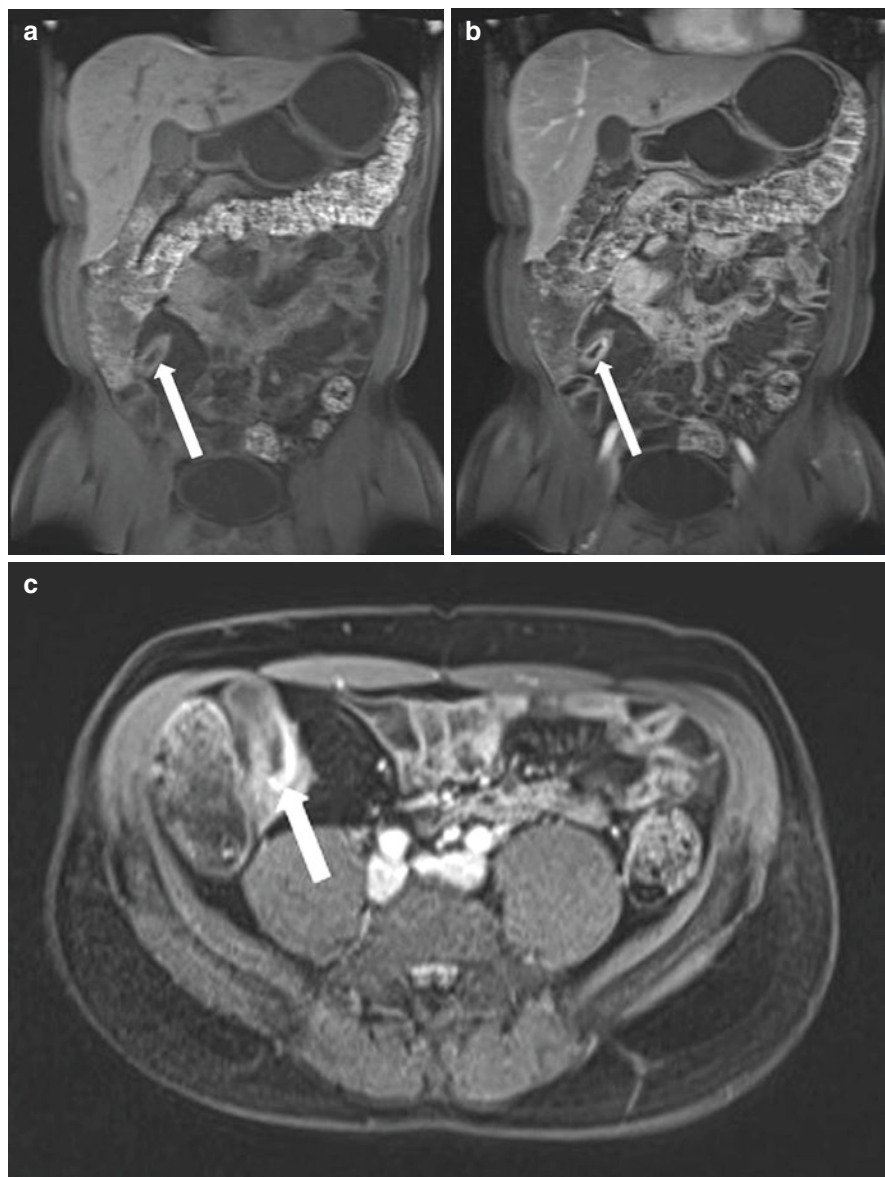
Typical hyper-enhancement of active terminal ileal (*arrow*) Crohn's disease after IV gadolinium administration. (a) Pre-contrast coronal T1-weighted sequences with fat saturation. Post-contrast (b) coronal and (c) axial T1-weighted sequences with fat saturation show avid predominantly mucosal enhancement of the terminal ileum
